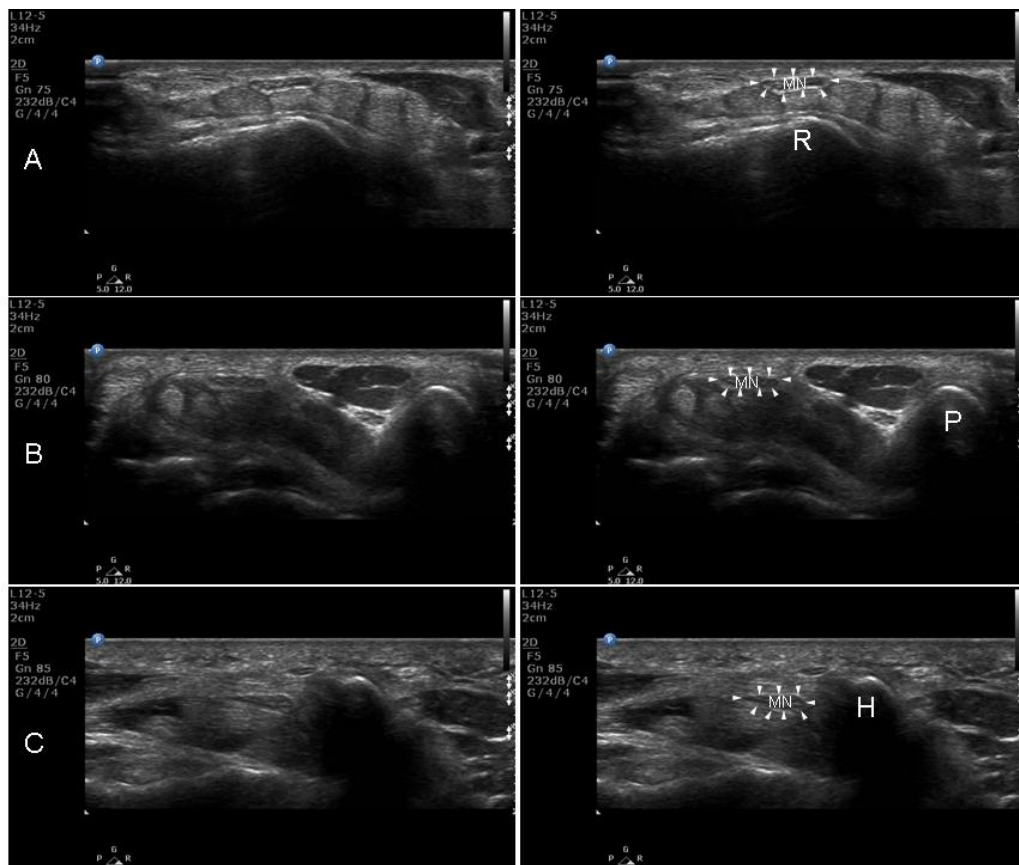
Sample ultrasound images at each image level
